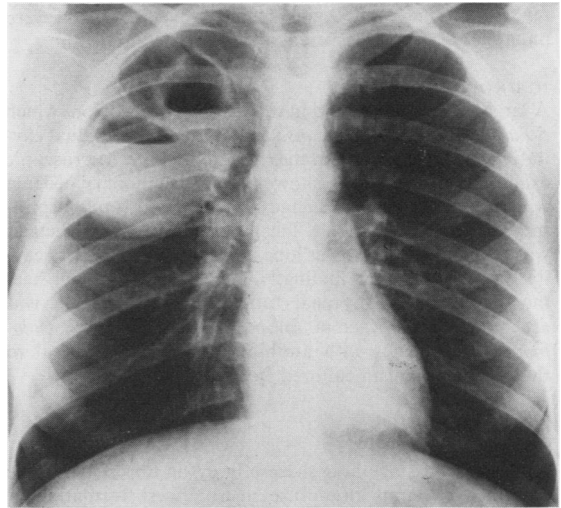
Chest radiograph showing the large abscess cavity in the right upper lobe.
